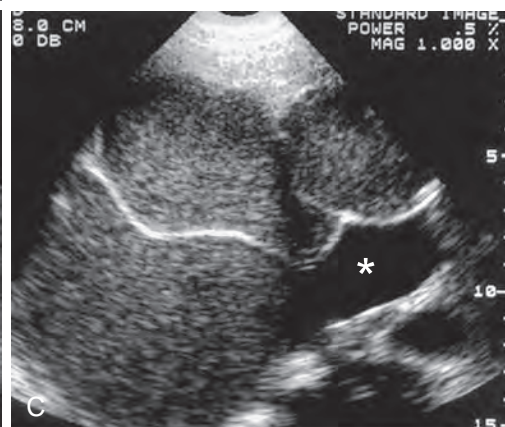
Biliary cystadenoma: sonographic findings. A. Transverse image of the liver shows a well-defined anechoic cystic structure with enhanced through-transmission. There are multiple echogenic tumor excrescences extending into the cyst lumen (arrows). B. Transverse image of the left hepatic lobe in a different patient reveals a complex anechoic cyst containing echogenic septa (straight arrow) and tumor nodules (curved arrow). C. Transverse image of the liver in a different patient shows a biliary cystadenoma composed of complex fluid containing diffuse low-level internal echoes. Echogenic septa course through the complex fluid. A portion of the tumor (asterisk) contains simple anechoic fluid. (From Levy AD, Murakata LA, Abbott RM, Rohrmann CA Jr: Benign tumors and tumorlike lesions of the gallbladder and extrahepatic bile ducts: Radiologic-pathologic correlation. *RadioGraphics* 22:387–413, 2002.)
